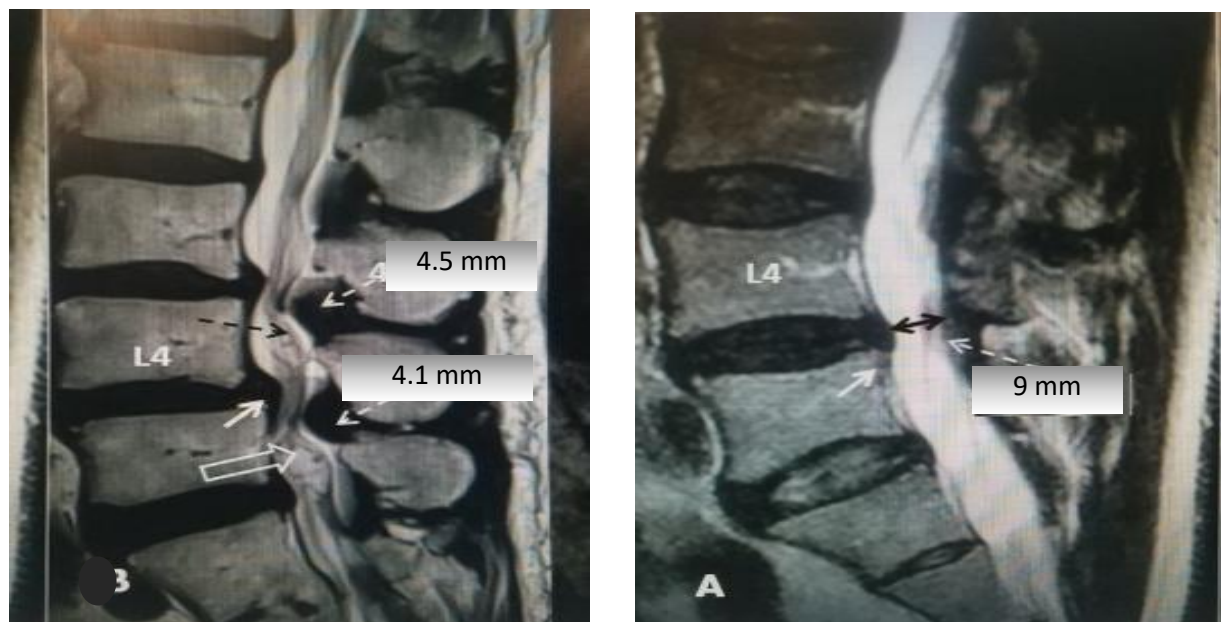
MRI scans compared in different patients with different grades of spinal stenosis
